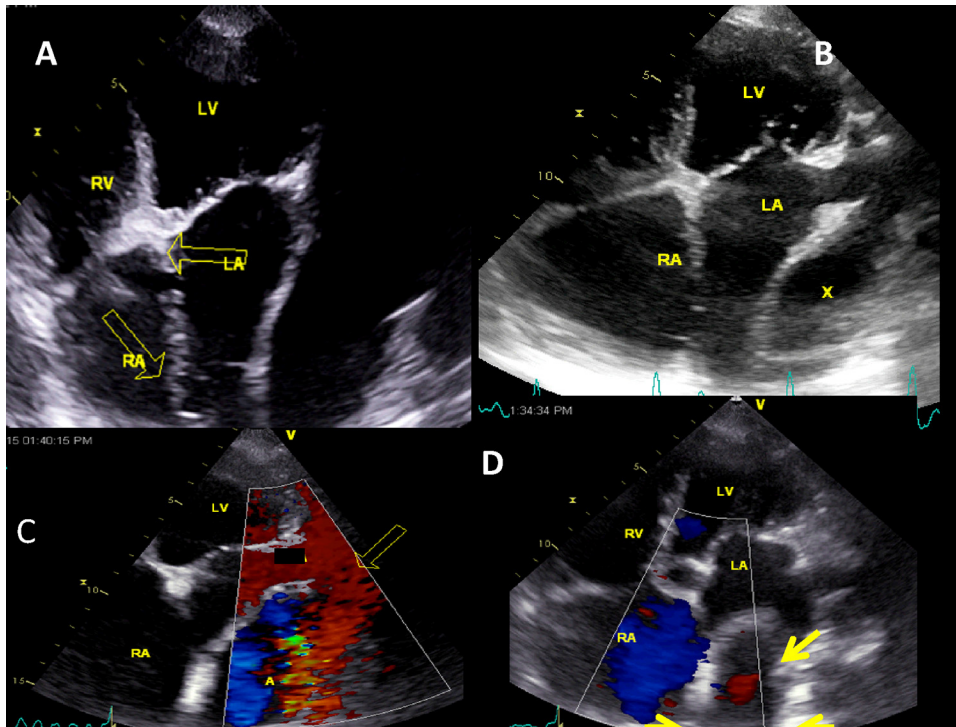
(Case #2): Multiple apical trans-thoracic echocardiographic views showing vertically split left atrium in 4-chamber views (X is the false chamber). In 5-chamber view, the false chamber or pseudo-aneurysm appears like a cystic mass (yellow solid arrows). (B, C) Communication between the two chambers situated above the posterior and lateral edge of the mitral annulus.
